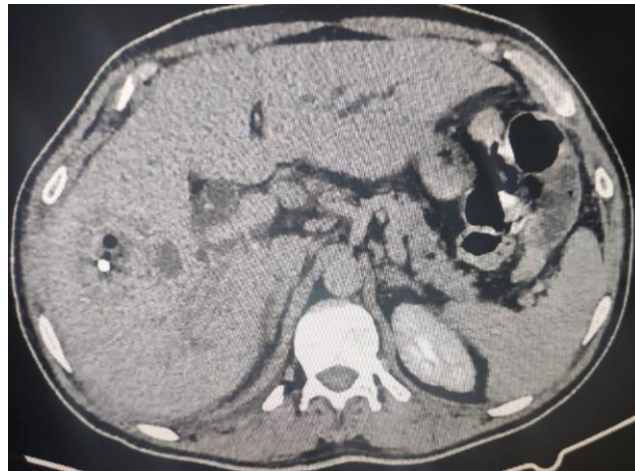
CT scan section, showing a hepatic abscess with a drain within it, no individualization of the gallbladder.
